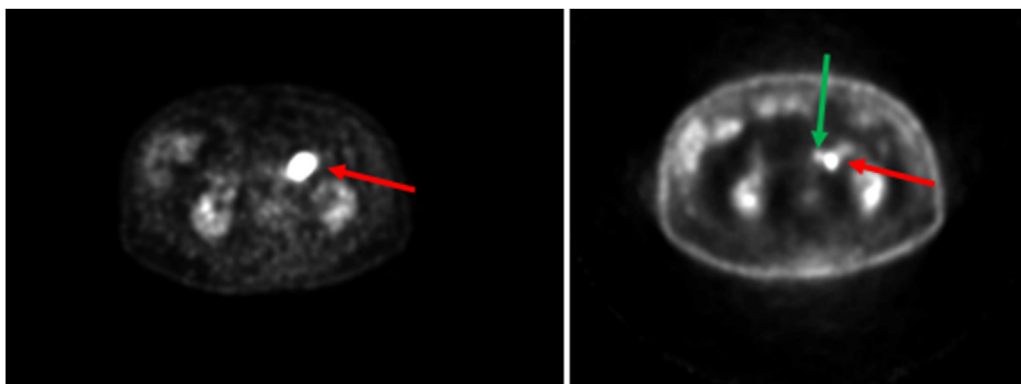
PET CT showing the duodenal neoplasia (red arrow) and the mesenteric lymph node (green arrow).
